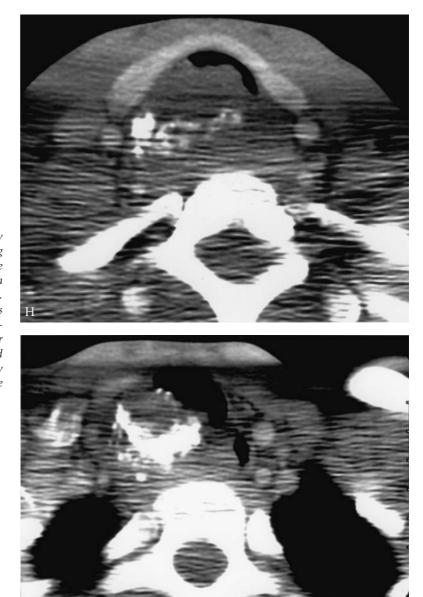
(CONTINUED) H, Computed tomography image of the same patient in Figure 14-20G, showing severe tracheal compromise. Note the calcification in the amyloid mass. The splayed shadow anterior to the trachea is the thyroid. I, Upper thoracic trachea is also invaded. Amyloid infiltrates the esophageal wall and narrows its lumen. A 5 cm length of the trachea and the anterior subglottic larynx were resected, plus esophageal muscular coats. Putty-like amyloid infiltrated the mediastinum and behind the posterior cricoid. Good result was finally achieved but a re-resection of the anastomotic stenosis, due to failure of healing of the first anastomosis, was required.
